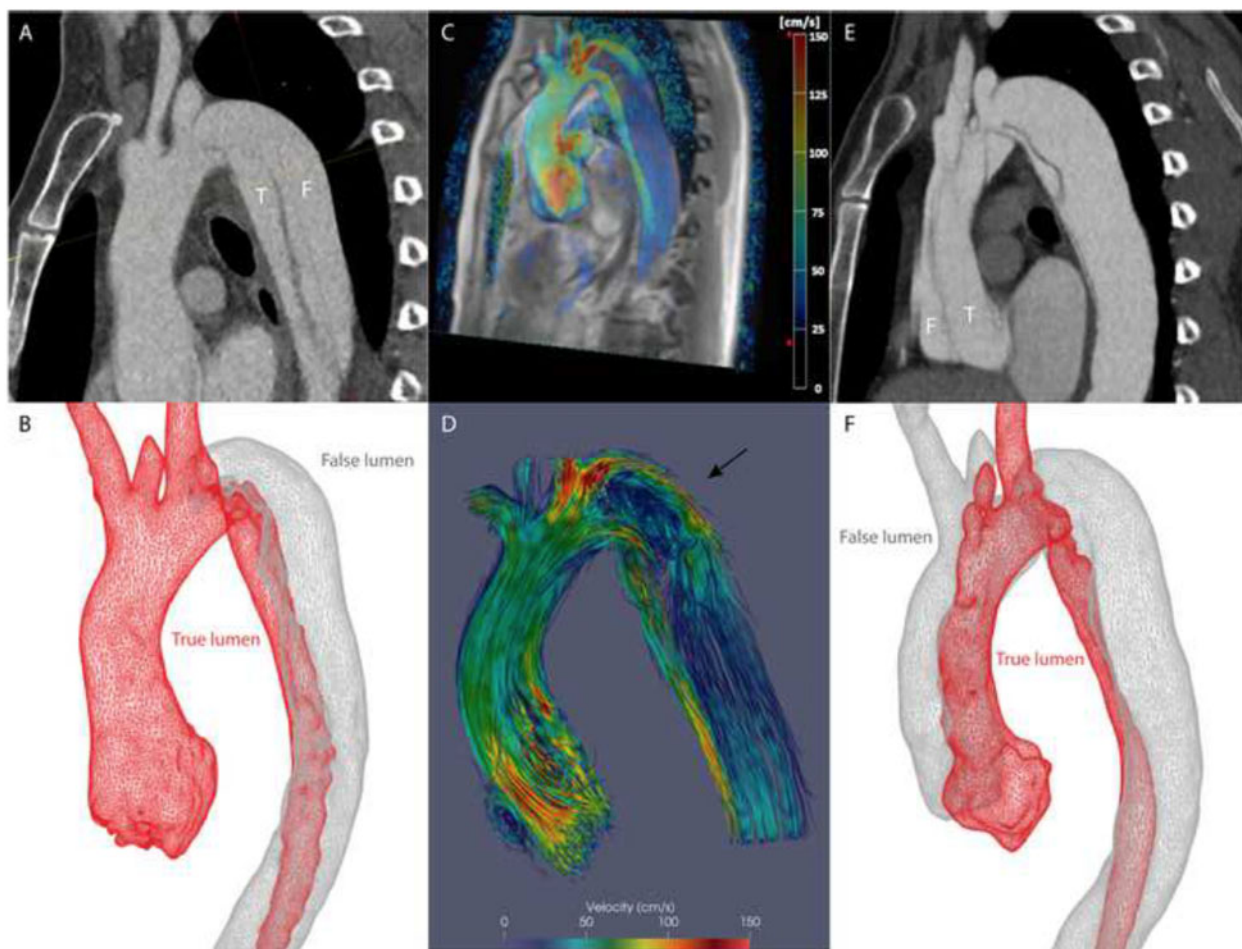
(A) $T = 0$: computed tomography image of type B dissection (T indicates true lumen, F indicates the false lumen) and (B) 3D segmentation. (C) $T_0 + 5.5$ weeks: 4D flow magnetic resonance imaging of type B dissection and (D) 3D peak-systole streamline visualization with vortical flow in the proximal false lumen (designated by the arrow). (E) $T_0 + 7.5$ weeks: computed tomography images of the type A dissection (T indicates true lumen, F indicates the false lumen) and (F) 3D segmentation. (C and D) Colour scale from blue (representing low velocity) to red (representing high velocity). Colour scale is provided next to the image.
